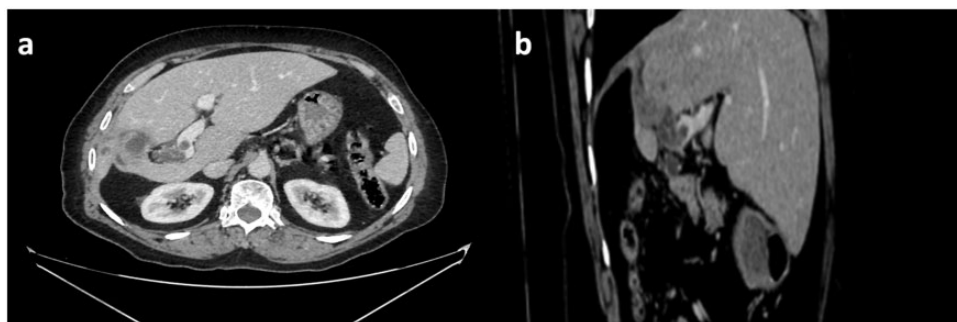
Abdominal CT showing a large LHC in the right liver. The cyst shows loss of fat planes with the right portal branch with exovesiculation on axial and sagittal sections (a and b) CT, computed tomography; LHC, liver hydatid cyst.
